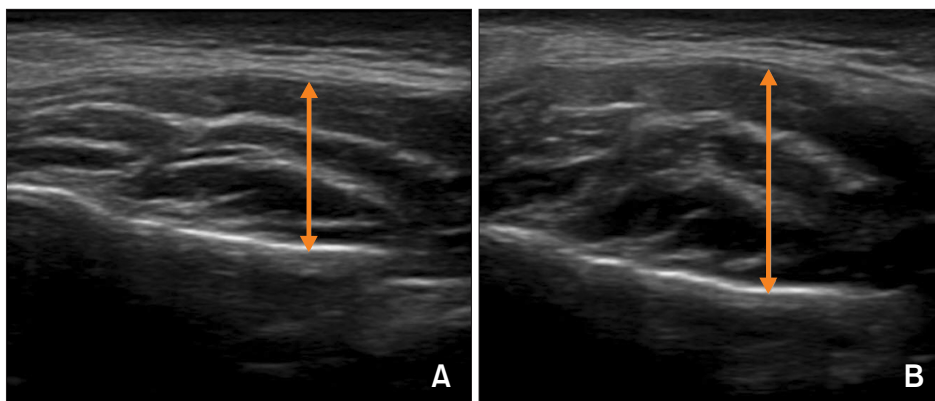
Masseter muscle on ultrasonography. (A) Masseter muscle in relaxed position. (B) Masseter muscle in clenched position.
